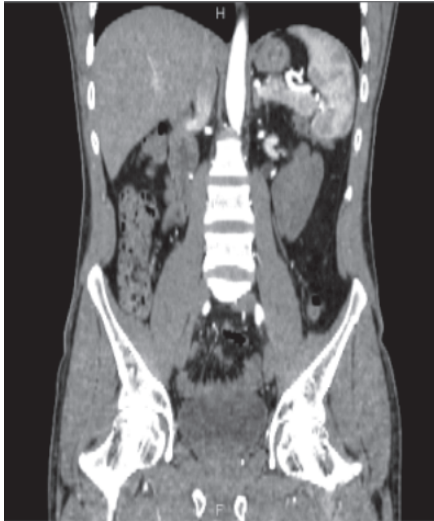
Coronal donor CT angiogram showing the arterial supply of the left kidney. All 3 arteries are evident in this image, the most proximal small upper polar artery (turquoise arrow), the main hilar artery (orange arrow) and the distal hilar artery arising from the lower aorta (yellow arrow).
